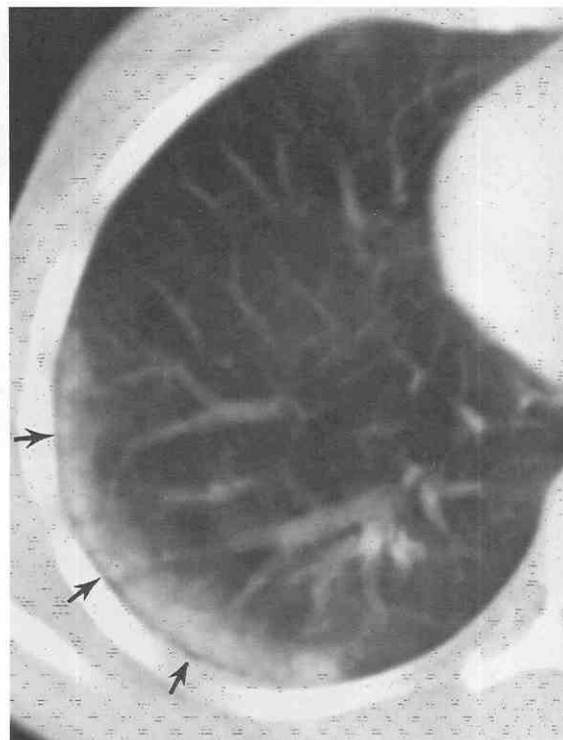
Pulmonary contusion in a 12-year-old girl after a motor vehicle accident. CT scan shows characteristic findings of contusion, including posterior location, crescentic shape, nonsegmental distribution, and subpleural sparing (arrows).
